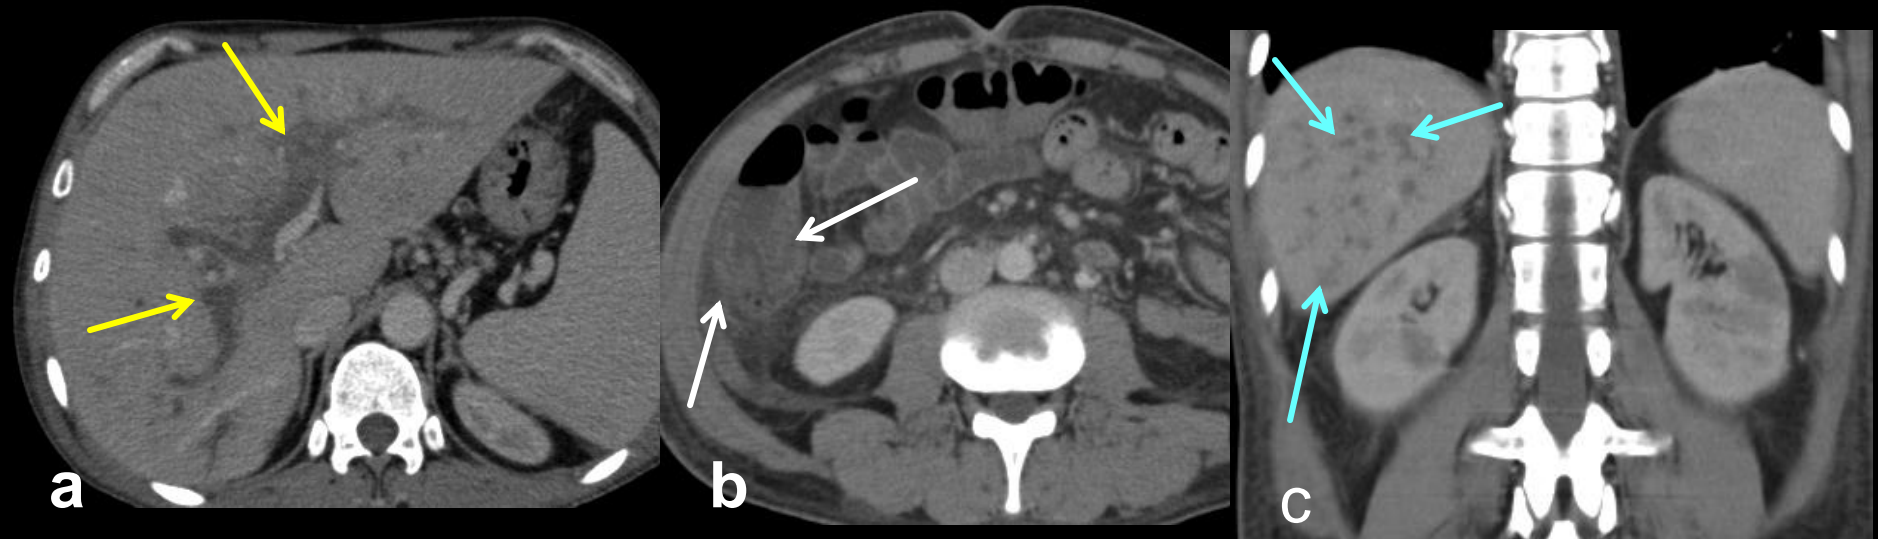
Transverse CT images (a,b) of a 46 year-old patient demonstrate septic thrombophlebitis of intrahepatic branches of the portal veins (yellow arrows) secondary to infectious colitis. Note mucosal hyperemia and submucosal edema of ascending colon (white arrows). Coronal image (c) of a follow-up CT examination showed several small liver abscesses (blue arrows). Multifocal liver abscess is considered to occur secondary to hematogenous spread.
